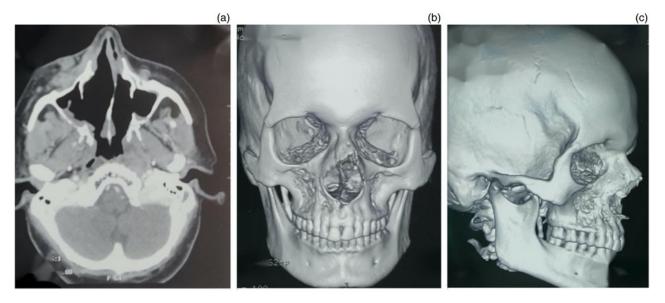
(a) Two-dimensional axial computed tomography (CT) image demonstrates soft issue density over anterior maxilla. (b & c) Three-dimensional CT images showing minor cortical erosion of bilateral anterior walls of maxilla.
